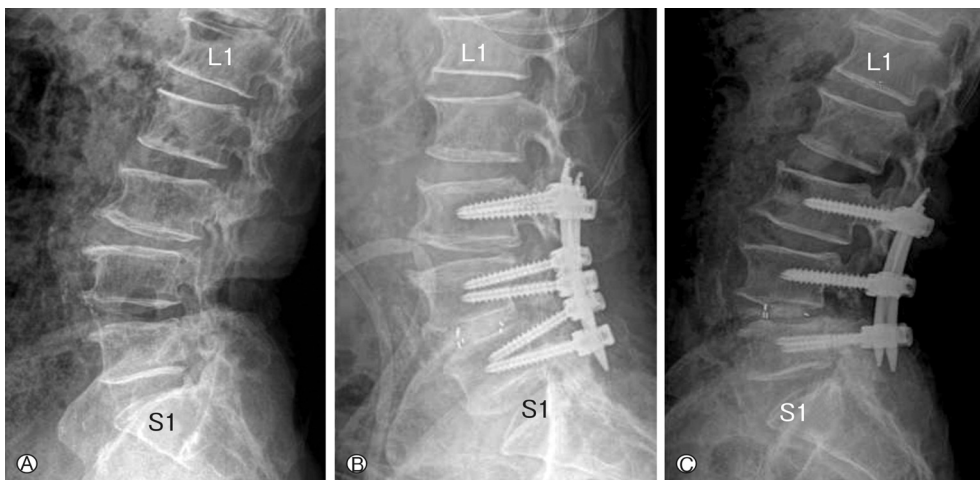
Series of lumbar spine of patient who showed no development of adjacent segmental degeneration (ASD) at the last follow up period. A: Pre-operative plain lateral X-ray showed degenerative retrolisthesis of L3 on L4. B: 3 months after operation (posterior lumbar interbody fusion (PLIF) on L4, 5 and posterolateral spinal fusion (PLSF) on L3-4-5 segments). C: At the last follow up period (1 year after operation), there was no change at adjacent disc space of L2, 3.
